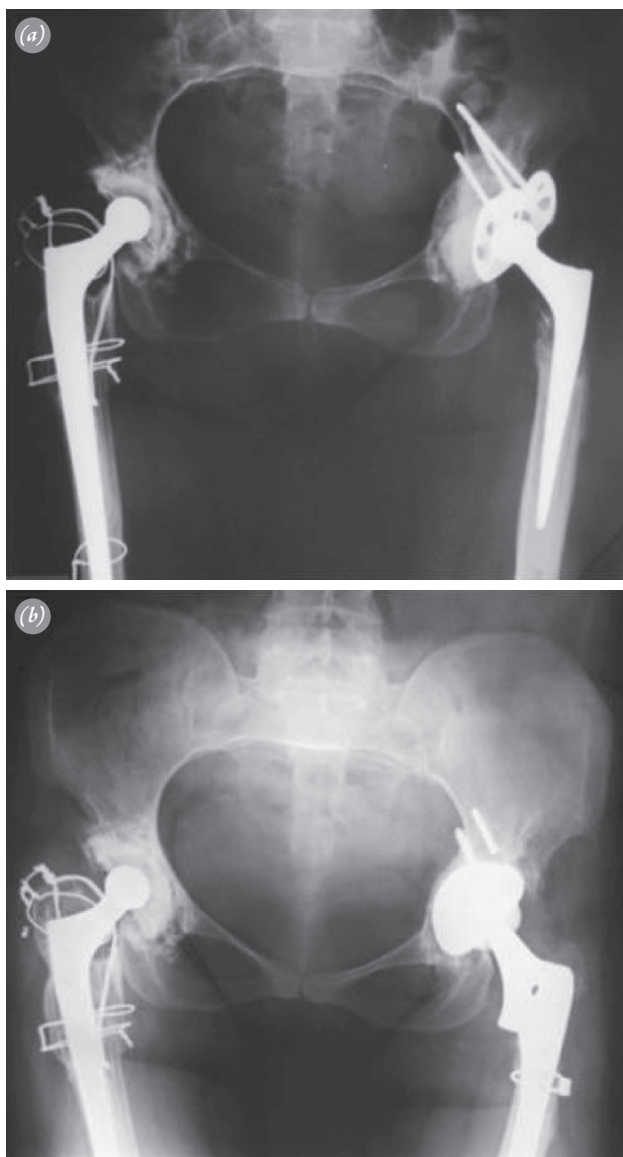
(a) Posterior-anterior direct radiograph showing that the bone tissue reserve is sufficient and that 1 screw had broke at Year 5 postoperatively after revision using ARR. (b) Posterior-anterior direct radiograph after revision was performed using porous coated components without requiring the use of ARR or BSAPC.
